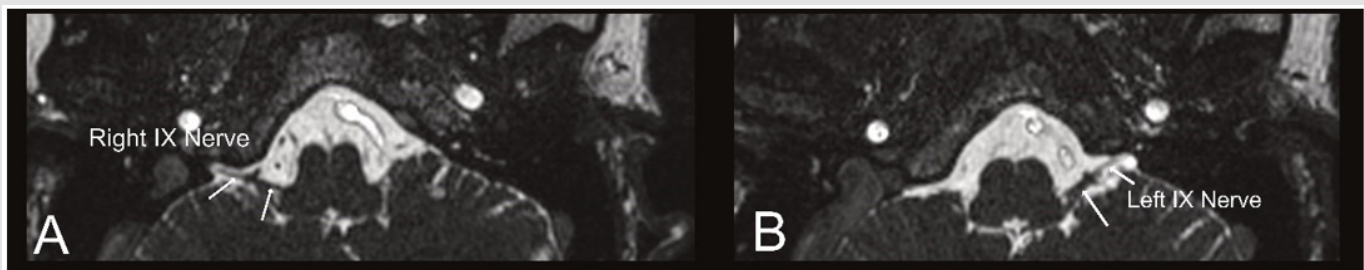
High-resolution CISS magnetic resonance imaging of the glossopharyngeal nerves demonstrating vascular contact without convincing neurovascular compression.
